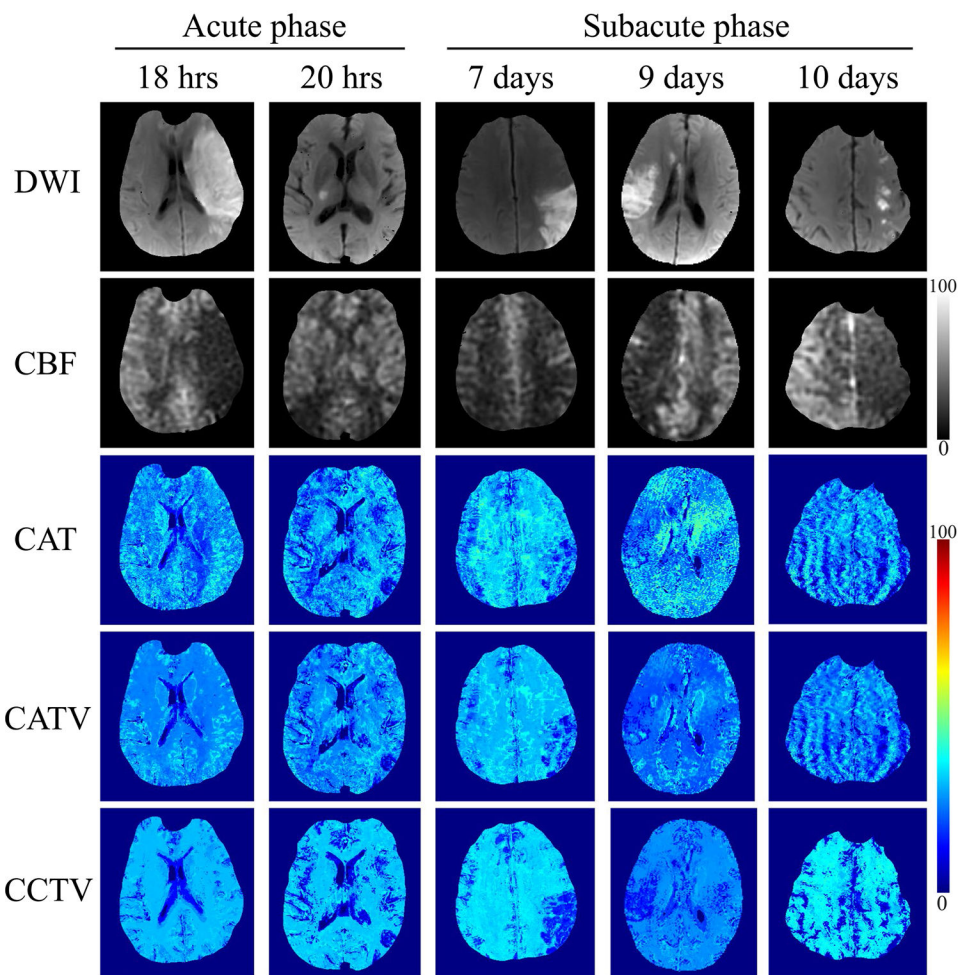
Comparison between the OEF obtained by QQ-CAT, QQ-CATV, and QQ-CCTV in 6 stroke patients imaged between 18 hours and 10 days post stroke onset. The QQ-CCTV shows more uniform OEF maps except for DWI-defined lesions compared with QQ-CAT and QQ-CATV. In the subacute phase patients, low OEF areas in QQ-CCTV agree better with DWI-defined lesions. The CBF maps are shown for reference in units of mL/100 g/min
